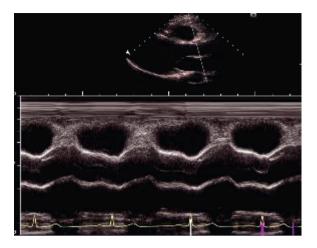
Echocardiographic M-mode image.
